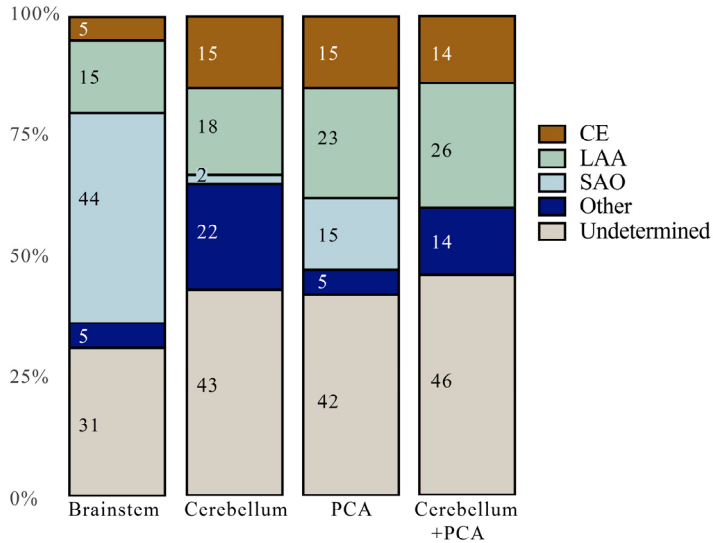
Lesion locations related to CCS subtype assignment in PCiS patients in MRI-GENIE. CE, cardioembolism; LAA, large artery atherosclerosis; SAO, small artery occlusion; PCA, posterior cerebral artery.
